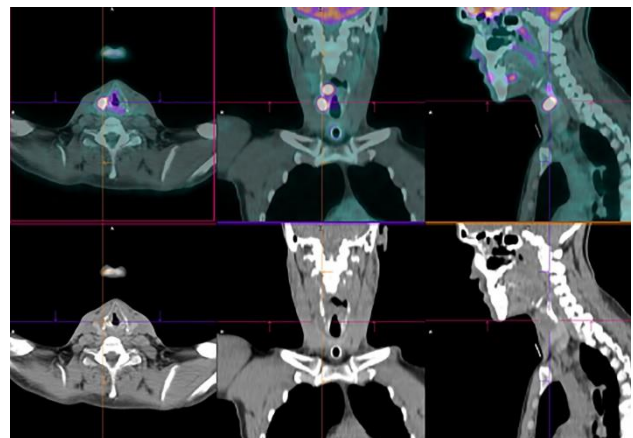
18-fluorodeoxyglucose PET-CT scan revealing moderate/high metabolic activity in two places in larynx.
